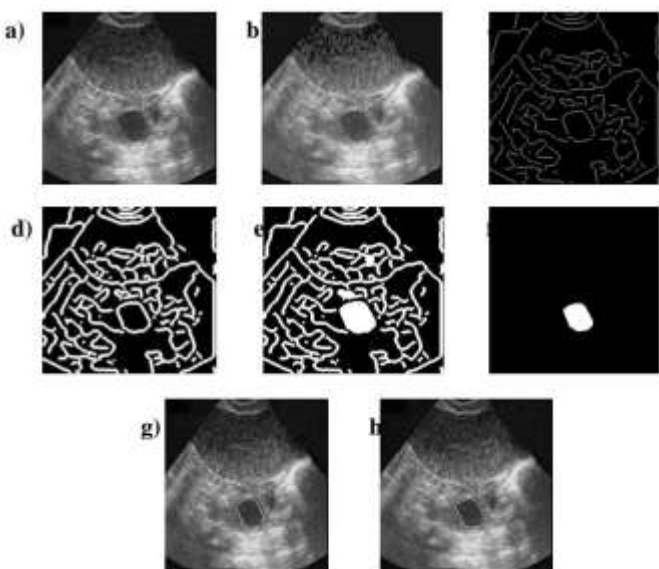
a) Input original ultrasound image of ovary (Fig.4(a)), b) Image after applying contourlet transform method (despeckling), c) Histogram equalized image after applying canny operator, d) Image after edge filling by dilation, e) Image after region filling, f) Final output image after applying erosion, g) Image showing recognized follicles(outlined in white) super imposed on the original
